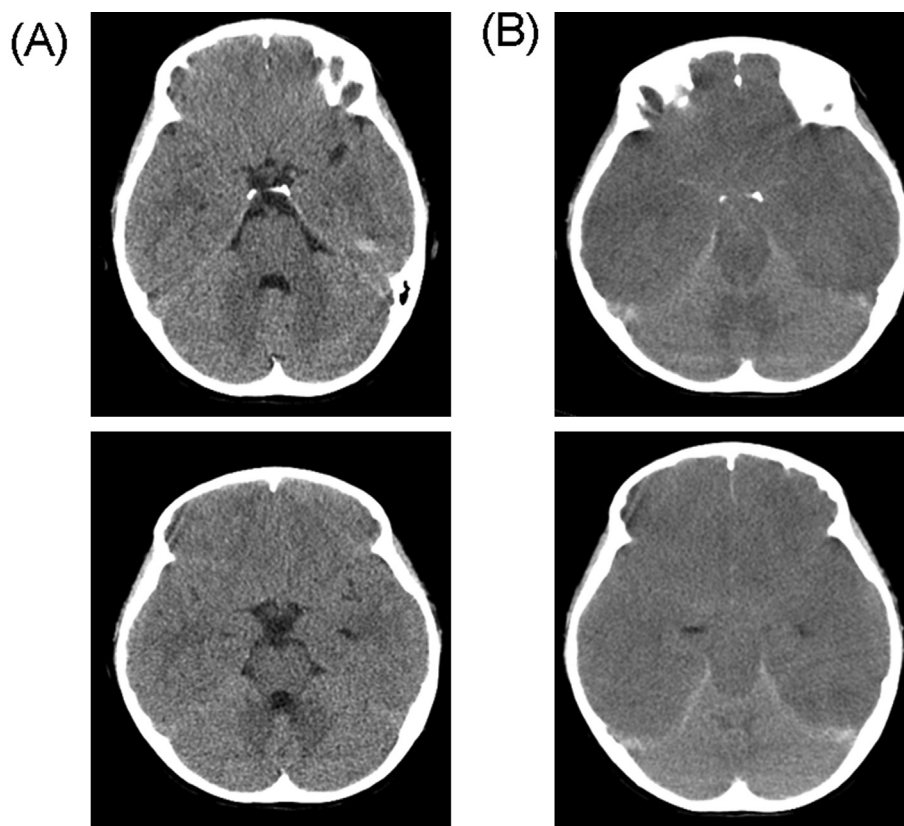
(A) Brain computed tomography of a 7-year-old girl with acute encephalitis showed a nonspecific finding initially, (B) but evidence of uncal herniation in follow-up imaging the next day.
